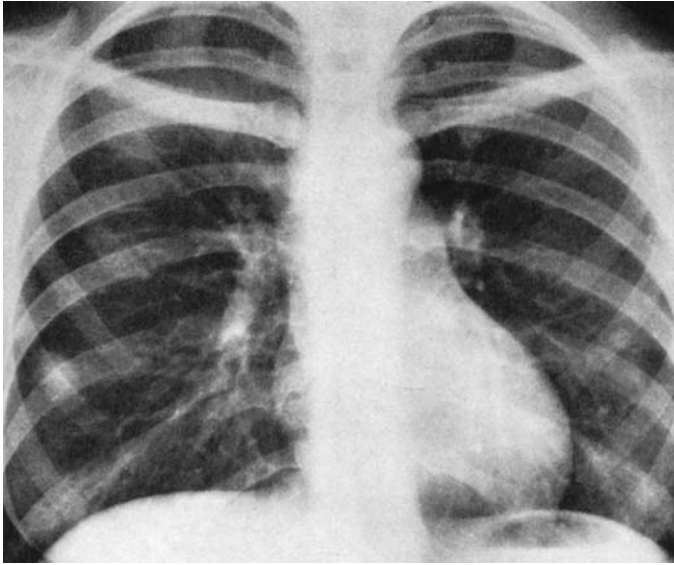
Case 1. Lung roentgenogram (R 1 in fig. 11). A lesion resembling a metastasis is visible in the right lung.
